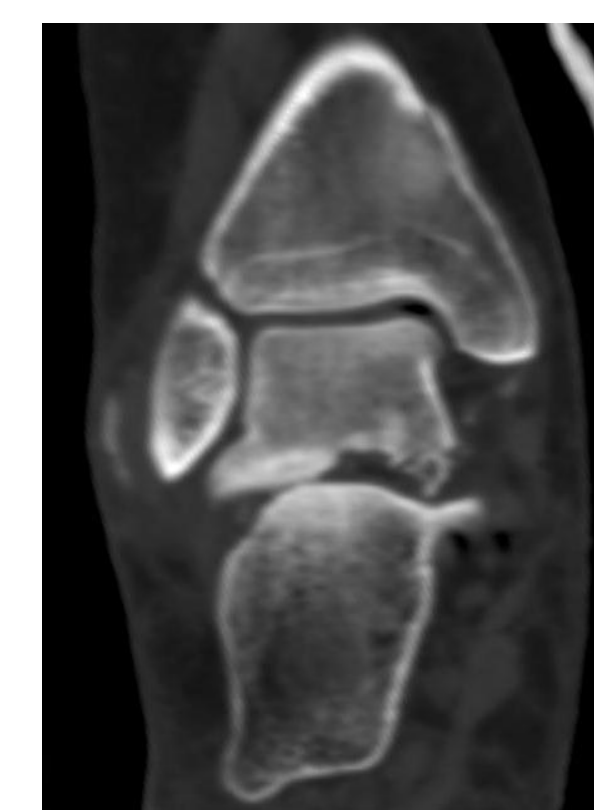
Post reduction CT
